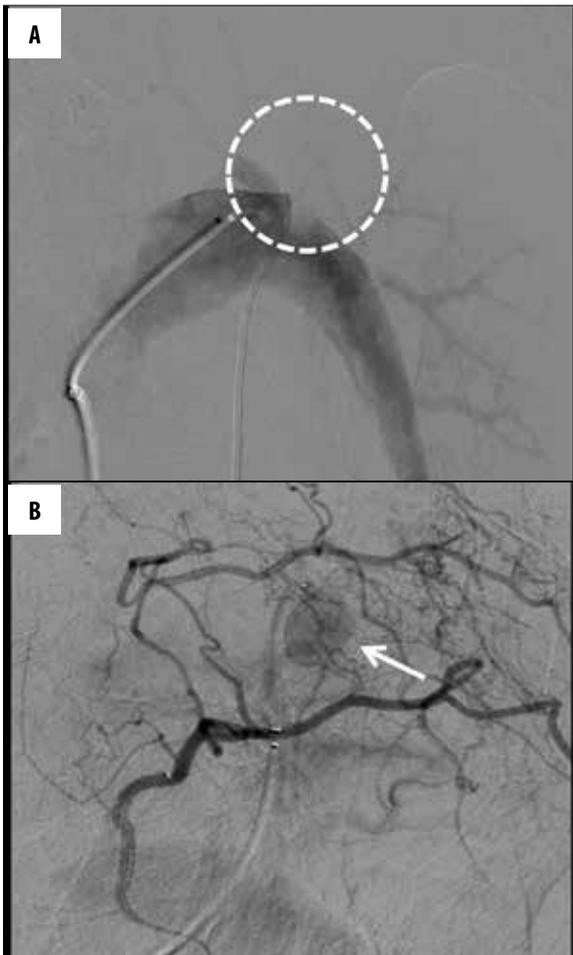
(A) Pulmonary angiography from the left pulmonary artery does not show the branch of the left upper lobe due to reverse flow from the systemic artery. (B) Systemic angiography from the fifth left intercostal artery shows the PAP (arrow). (C) Coronal maximum intensity projection CT image during angiography from the fifth left intercostal artery shows the posterior spinal artery (arrow). (D) A microcatheter was successfully advanced to the distal site of the PAP, and PAP was visualized obviously (arrow). Then, coil embolization was performed. (E) After coil embolization, angiography from the fifth left intercostal artery shows the disappearance of the PAP.
